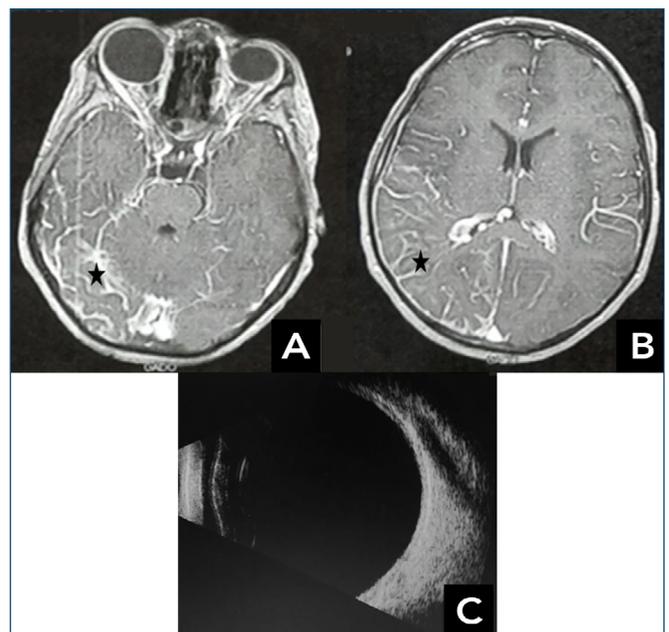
(A, B) Axial T1 weighted magnetic resonance imaging with gadolinium contrast showing contrast enhancement asymmetry with hypersignal on the right side with abnormal venous drainage. (C) Ocular ultrasound of the right eye showing elongation of ocular diameters.
